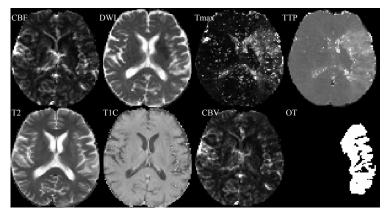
SPES MRI modalities. The images show the MRI modalities used as input channels to the CNN model for SPES dataset.
